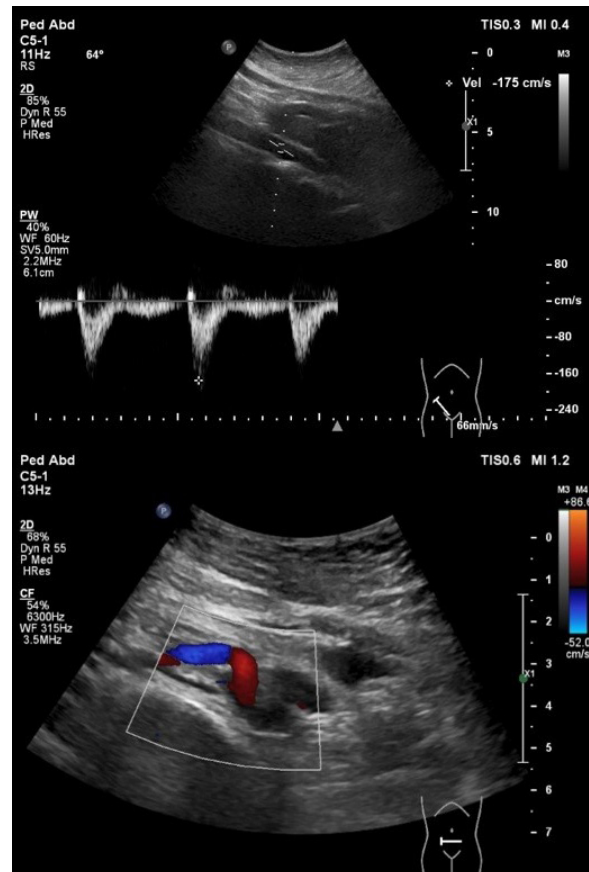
Doppler ultrasonography of renal artery with an empty bladder: no bending or stenosis visible
